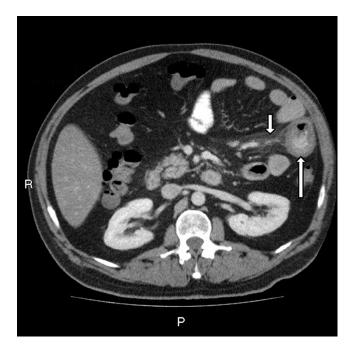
Axial image of a computed tomography (CT) of the abdomen with intravenous and oral contrast, in the portal venous phase. Marked concentric thickening of a proximal jejunal loop with reduced attenuation of the wall (long arrow), and localised stranding of the jejunal mesentery (short arrow).
